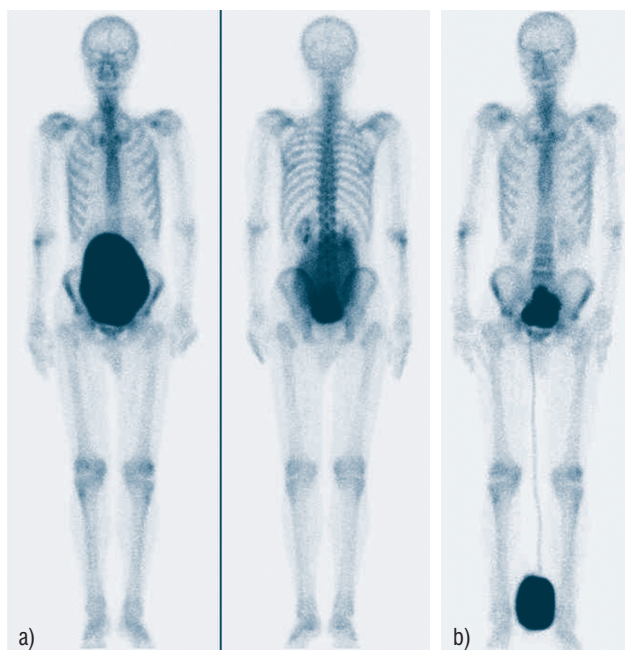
a) Whole body ^{99m}Tc -MDP scintigraphy showing a gigantic urine bladder. Anterior and posterior views. b) After urinary tract catheterization, an anterior whole body image was obtained.
